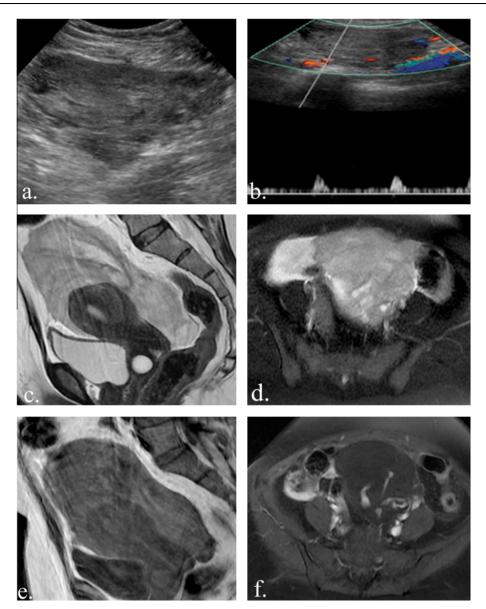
Pelvic hematoma: a 49 year old female patient presented to the emergency department with acute pelvic pain. Patient gave history of previous cardiac valve replacement and receiving anticoagulant therapy. Pelviabdomial ultrasound was done for the patient. (a & b) Gray scale pelvic ultrasound (a) as well as color Doppler examination (b) revealed a sizeable pelvic mass with inhomogeneous echotexture, blood vessels were seen traversing it. There was also mild amount of perihepatic and perisplenic free fluid seen on abdominal ultrasound (not shown). It was interpreted as an ovarian origin vascular mass lesion with associated ascites, for further MRI characterization. Sagittal T2 and axial T2 fat sat revealed a large pelvic mass seen insinuating the uterus displaying intermediate signal intensity with hyperintense foci. (e) Sagittal T1 weighted image revealed hyperintense foci denoting blood in the subacute stage. (f) Axial T1 weighted image post contrast administration revealed lack of enhancement with blood vessel seen traversing the hematoma. Pelvic hematoma was confirmed at surgery.
